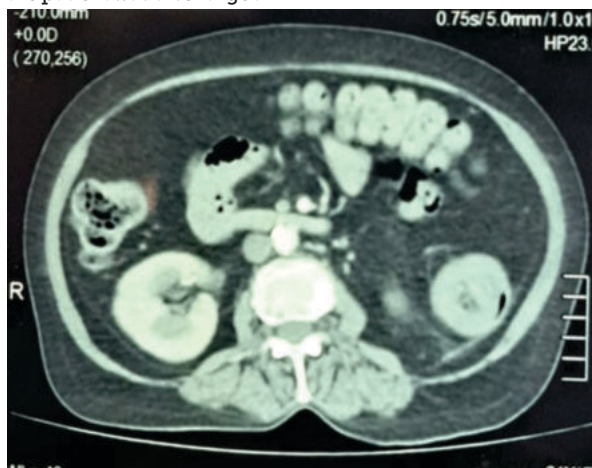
[A] CT showing Descending colon intussuseption
